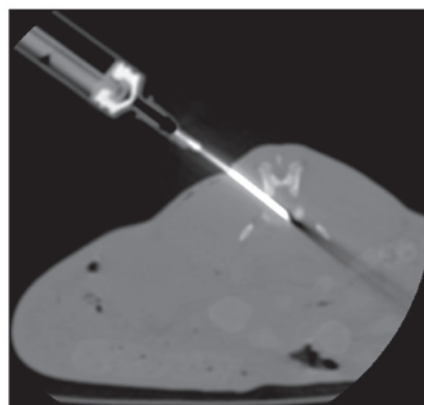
Computed tomography-guided percutaneous needle puncture technology.
